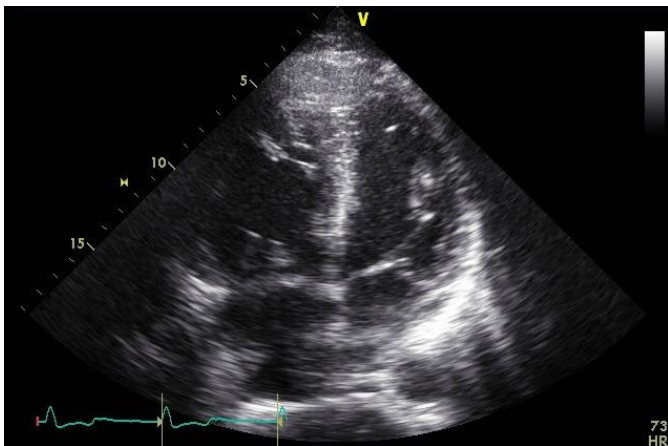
Transthoracic echocardiogram image with 4-chamber view showing the enlarged right ventricle.
